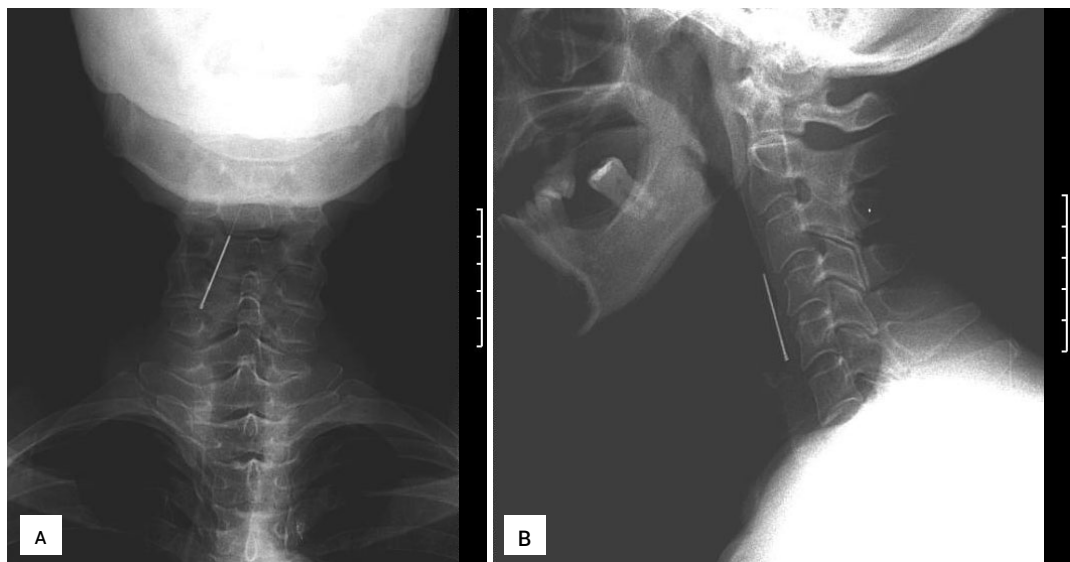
X-ray shows the needle located in the hypopharynx with its bulbous end facing downwards (frontal and lateral views, A and B, respectively). Written informed consent was obtained from the patient for X-ray publication.
